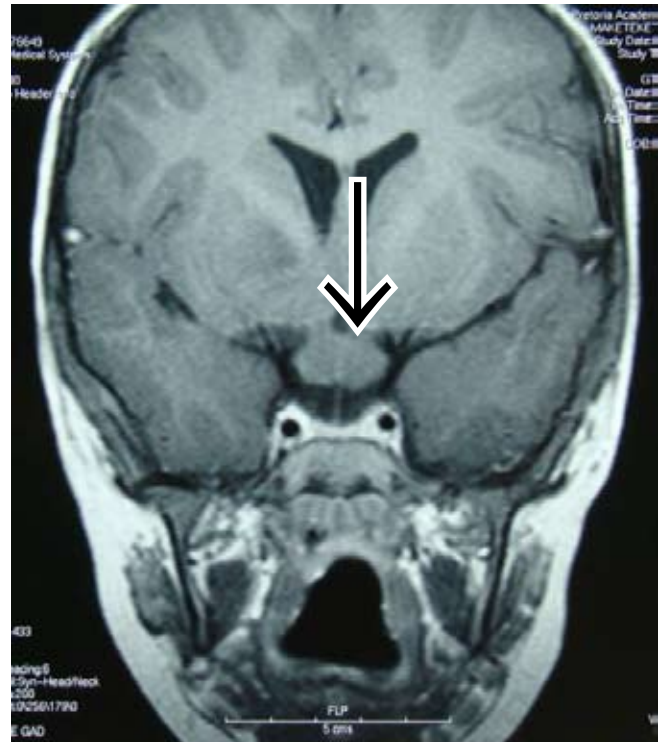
Coronal T1-weighted MRI demonstrates chiasmatic glioma in a patient with NF1.
